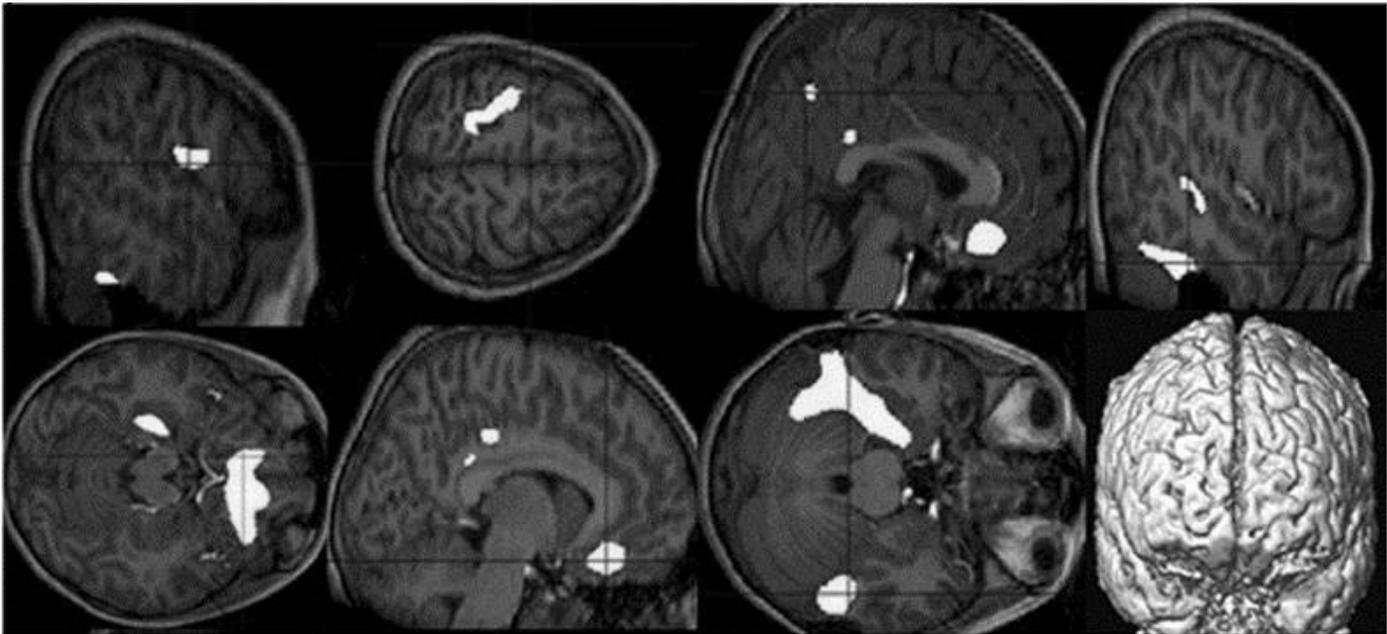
A MRI study by Carmona et al. (20) found region reductions in gray matter throughout the cortex and cerebellum. Highlighted areas are those that show smaller gray matter volume in ADHD children. These areas include the left precentral, paracentral, and postcentral gyri, as well as the right rectal, frontal inferior orbital, and frontal superior orbital gyri. Bilateral decreases in the cerebellum are also seen. (Reproduced with Permission)
